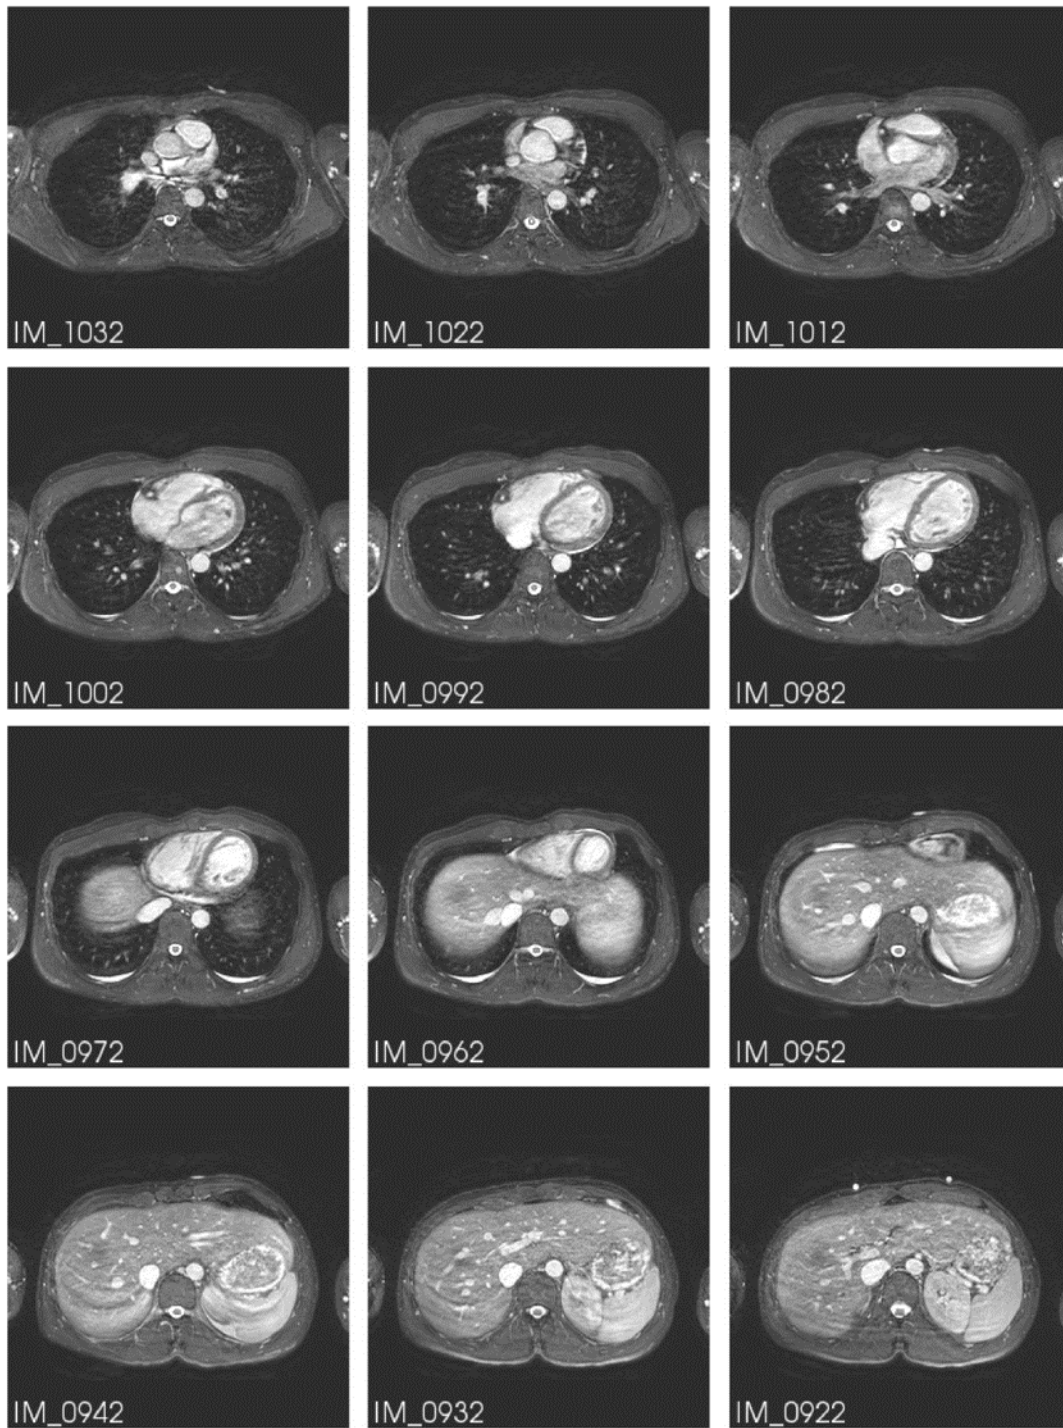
High resolution MRI series 701 of a torso with a heart at diastole, used for the first model. The MRI is from the publication by Prof. Hans Koch et al. [Koc+11].
